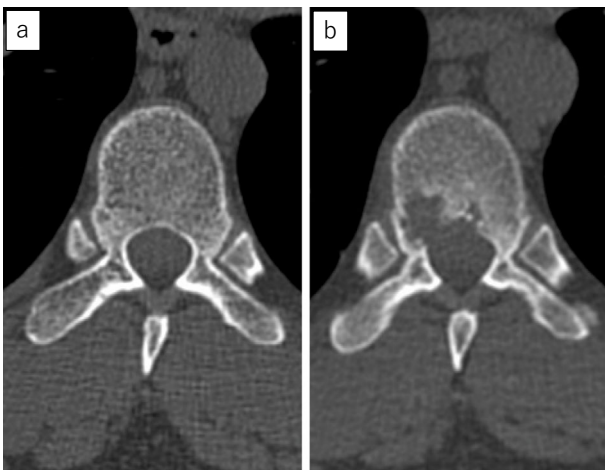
Bone conditions observed via chest computed tomography. No abnormalities were seen three years before the onset of symptoms (a). Osteolytic changes in the ninth thoracic spine at the time of the diagnosis (b).
